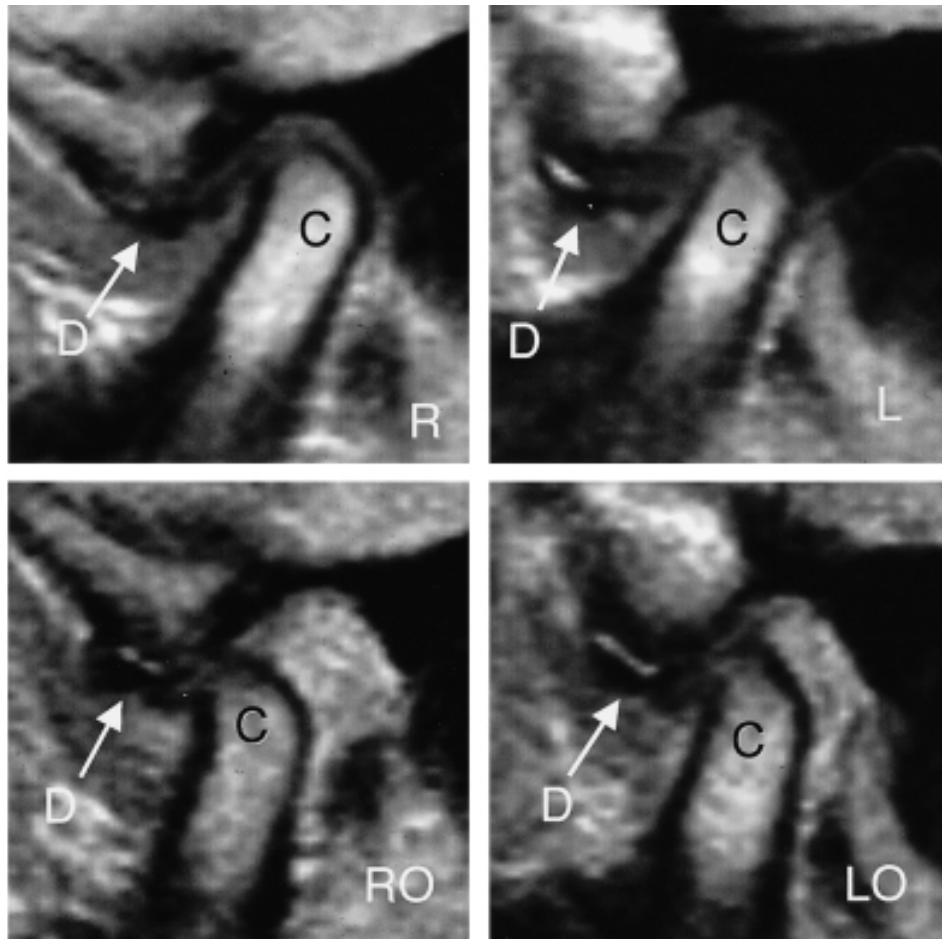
Magnetic resonance image photographs at 12 month after first examination (age 12 years, 9 months). The articular disks located in front of the both condyles (white arrows). Continuity of cortical bone was lacking on the top of condyles (black arrows). Erosive bone change was suspected. (D: disk, E: erosion, RC: right closed, LC: left closed, RO: right open, LO: left open).
